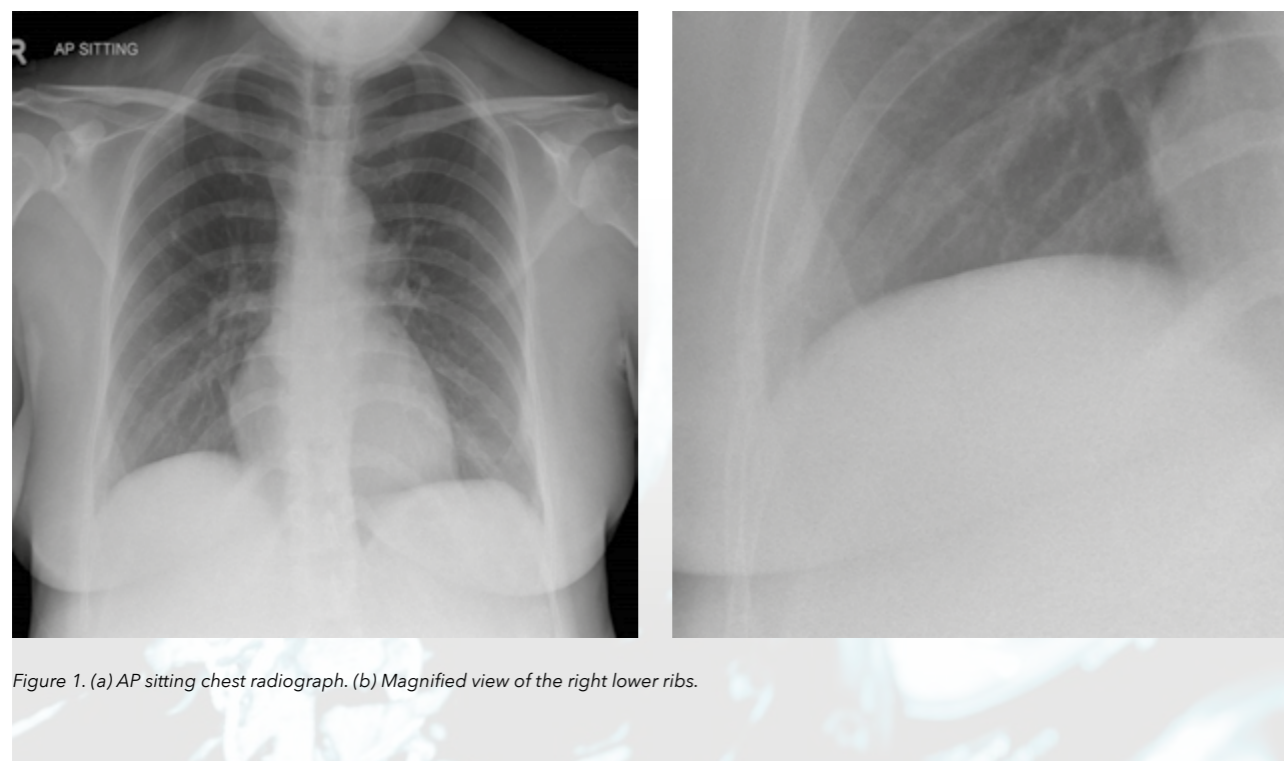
(a) AP sitting chest radiograph. (b) Magnified view of the right lower ribs.
